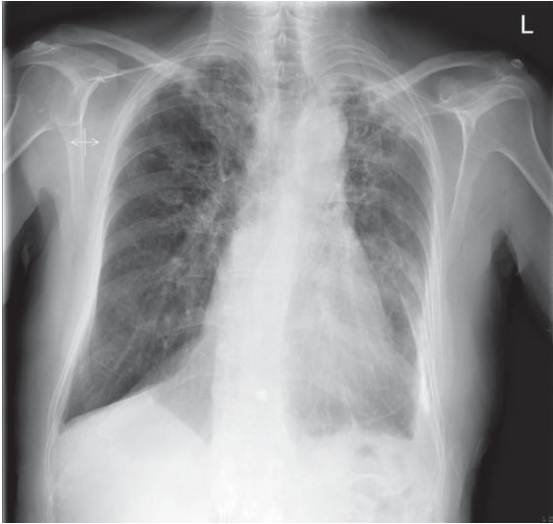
Chest X-ray of a patient with pulmonary TB.
